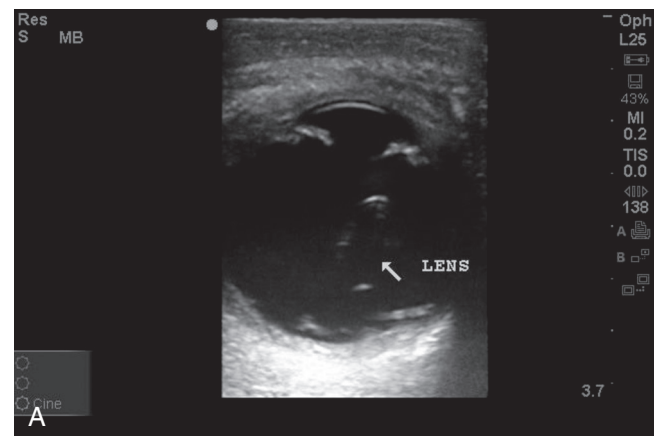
A, Ocular ultrasound showing lens dislocation. B, Dislocated lens with edge visible. (A, Courtesy Douglas Brunette, MD. B, Courtesy Jeffrey Lee, MD, University of California San Diego.)
